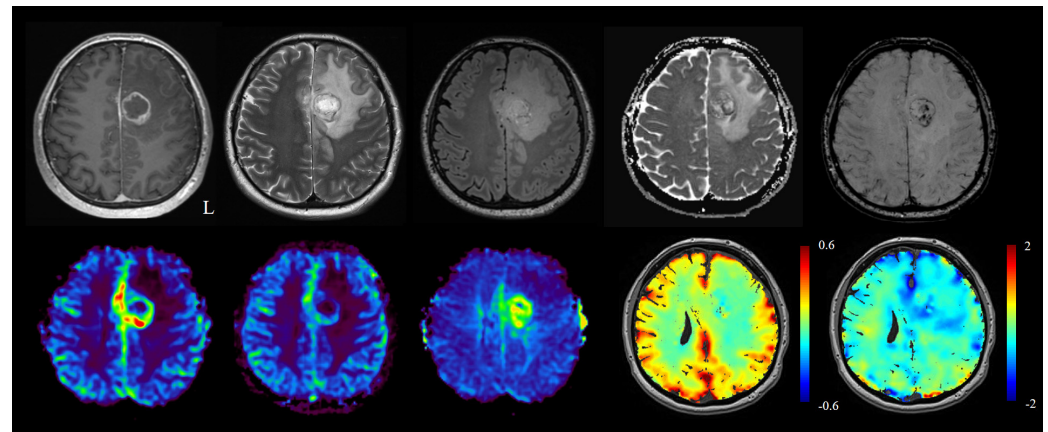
Standard MRI sequences, top row from left to right: T1 contrast-enhanced, T2, fluid attenuated inversion recovery (FLAIR), diffusion-weighted imaging (DWI), and susceptibility-weighted imaging (SWI). Perfusion MRI and advanced sequences, bottom row from left to right: CBV, CBF, MTT, BOLD-cerebrovascular reactivity (CVR), and hypoxia-enhanced BOLD MRI.
